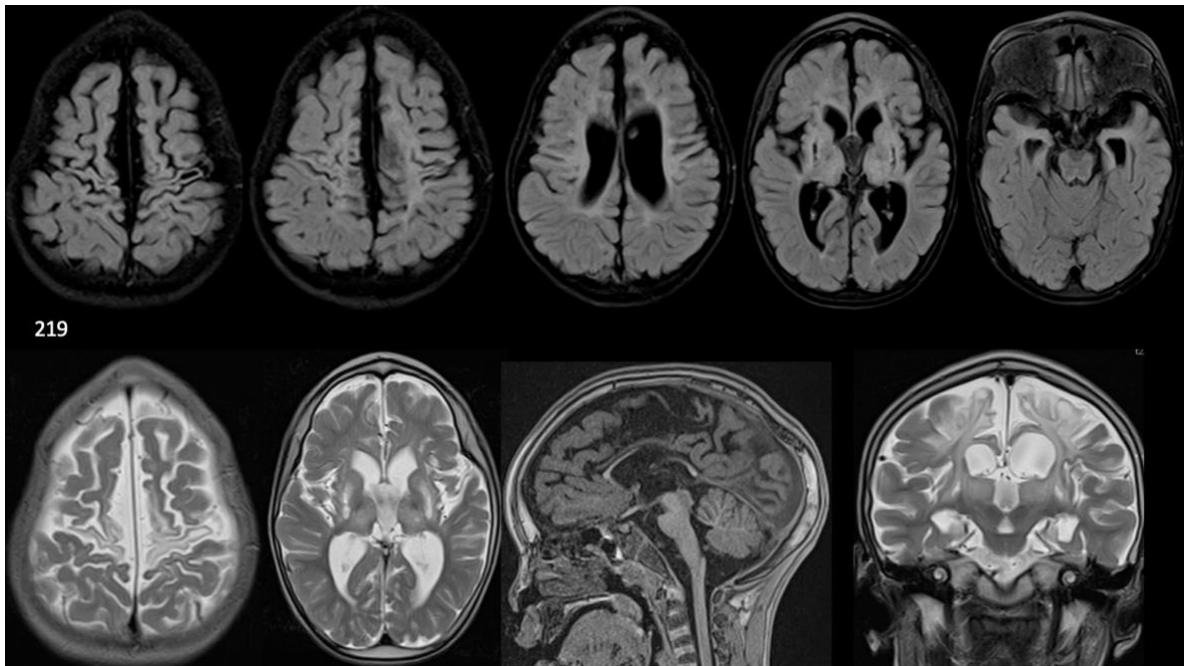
Collage of MRI images obtained for patient 219
